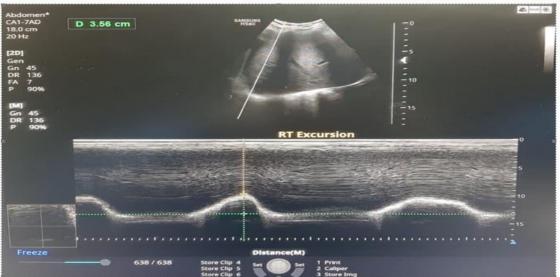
Ultrasound examination of the diaphragm showing measurement of diaphragmatic excursion ; upper part D mode , lower part M mode
